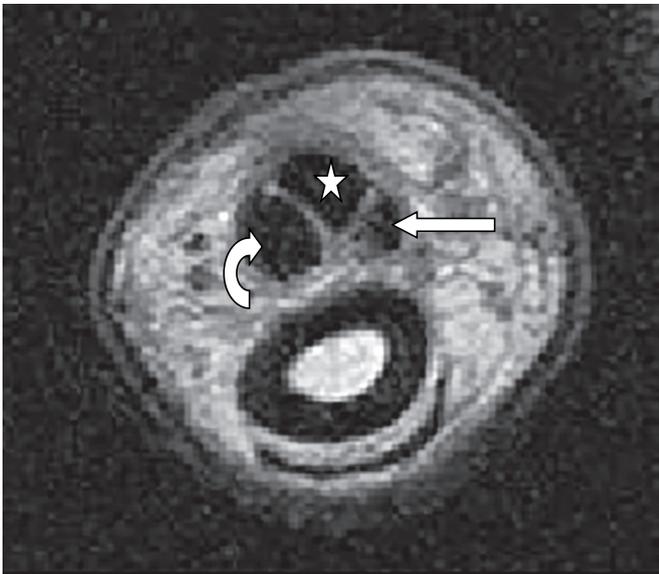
Same patient. Axial proton density MR image demonstrates a tear of the oblique pulley (Ao) at the level of the proximal phalanx with thickened/scarred and retracted radial (curved arrow) and ulnar (arrow) limbs of the pulley. The flexor pollicis longus (FPL) tendon (star) is intact, but volarly displaced from its expected location.
